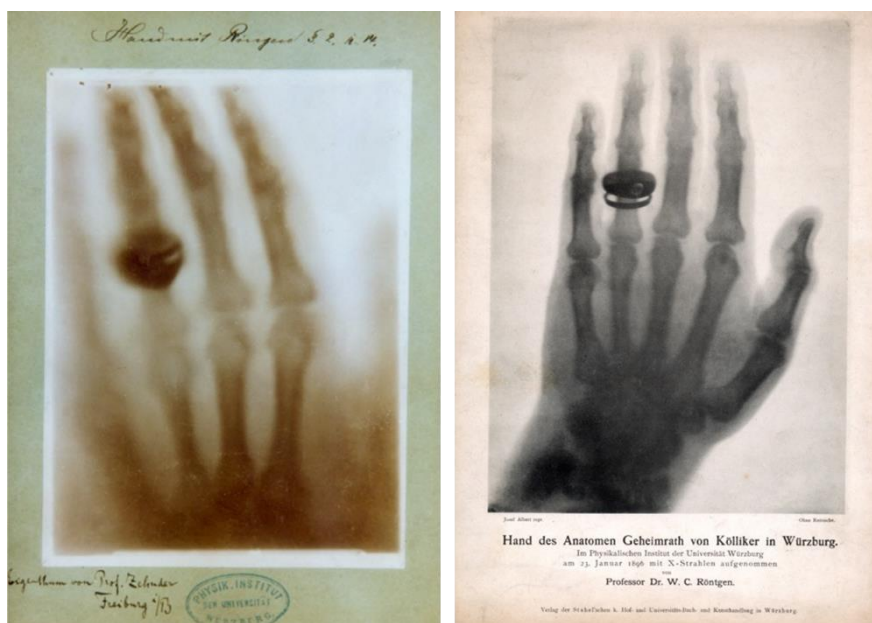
Left: X-ray of Anna Bertrand Röntgen's hand (1895-12-22). Right: X-ray of Albert von Kölliker's hand (1896-01-23).
